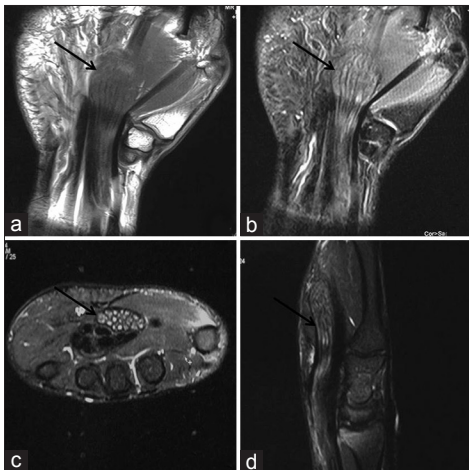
Magnetic resonance imaging of the patient shows hypertrophied soft tissue with intermediate signal and intervening areas of bright (fat) signal of coronal short TE/TR images (a). Coronal, axial, and sagittal fat suppressed long TE/TR images (b-d) shows suppression of the abnormal intraneural soft tissue with compressed bright nerve fibrils giving a typical “spaghetti appearance of gigantic median nerve”
